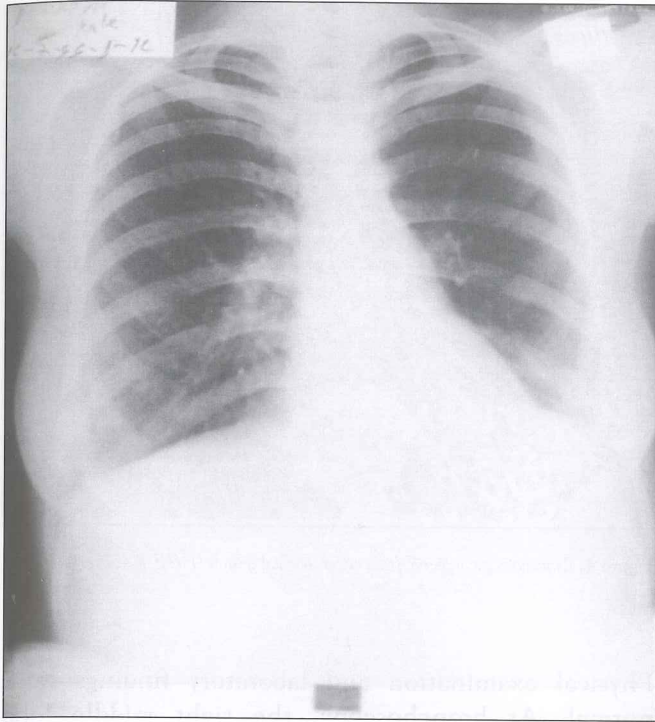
Chest x-ray (1999)
